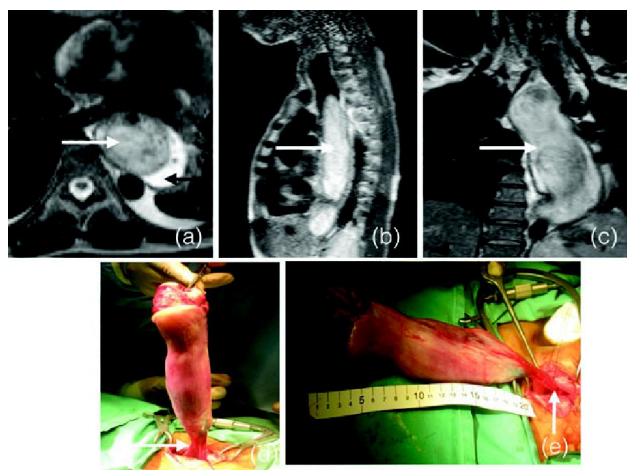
The mass has heterogenous signal intensity as seen in axial (a), sagittal (b) and coronal (c) of MRI images. Intra operative images (d) and (e) showed the stalk (arrow) and necrotic area at the inferior aspect of the mass. The length of the mass was approximately 25 cm
